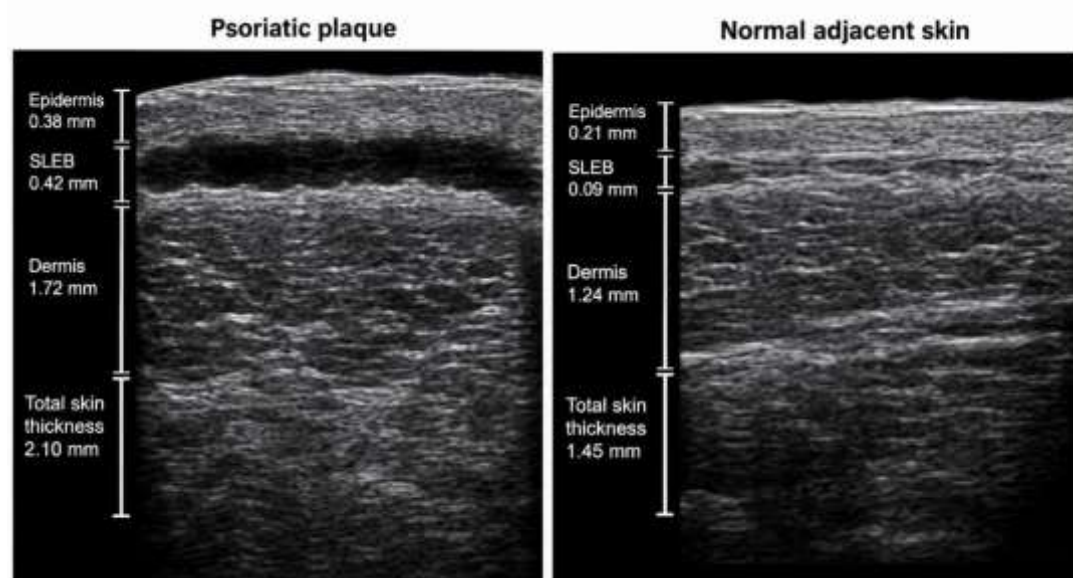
High-frequency B-mode ultrasonography demonstrating increased epidermal and dermal thickness and a prominent subepidermal low-echogenic band in a psoriatic plaque compared with adjacent normal skin.
